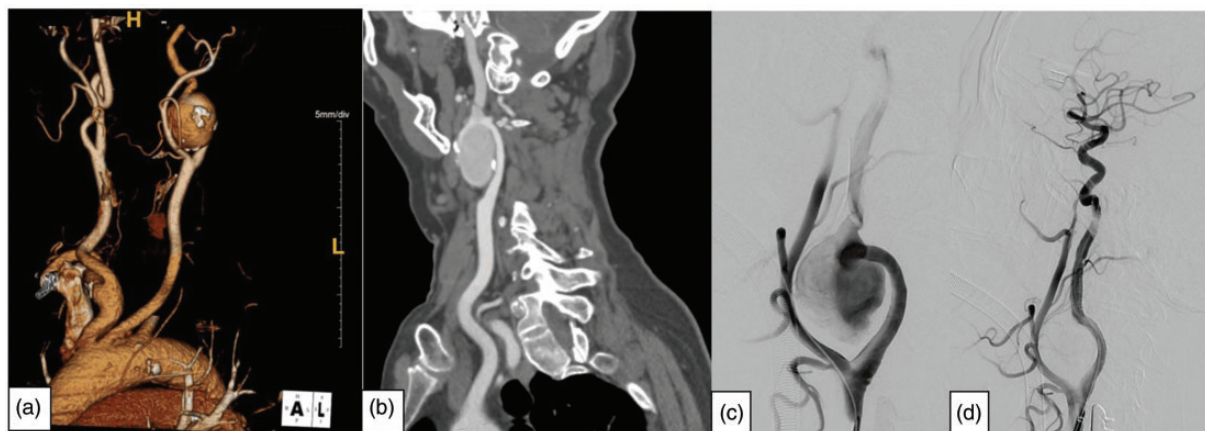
(a) Computed tomography angiography of left internal carotid artery aneurysm. (b) The Maximum intensity pixel reconstruction of the ECAA. (c) Preoperative angiogram showed aneurysm of the extracranial carotid artery. (d) Postoperative angiogram showed complete exclusion of the aneurysm and blood flow restore of the internal carotid artery.
